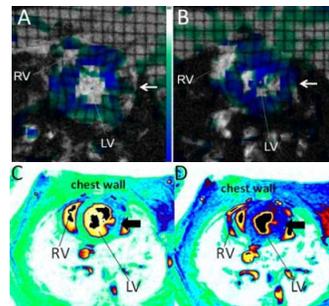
(A&B) Circumferential strain (Ecc) map, derived from tagging MRI; and (C&D) 1st-pass perfusion with bolus Gd administration, of (A, C) a untreated and (B, D) an Intralipid-treated IRI heart.
